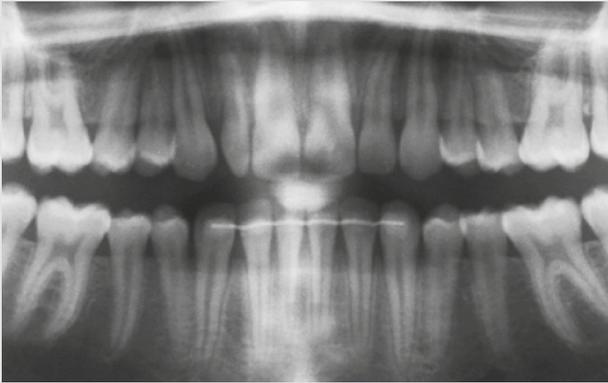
Initial radiograph. The maxillary peg-shaped right lateral incisor is perfectly placed during the orthodontic treatment. The main consideration is to provide good support to the mesial papilla by the mesial root surface of the lateral incisor and the distal surface of the central incisor. Ideally and to avoid any root kissing, a space of no less than 1 mm should be maintained for the interdental bone septum; distally, this space can be larger, since a slightly flatter papilla is less critical at this location.
